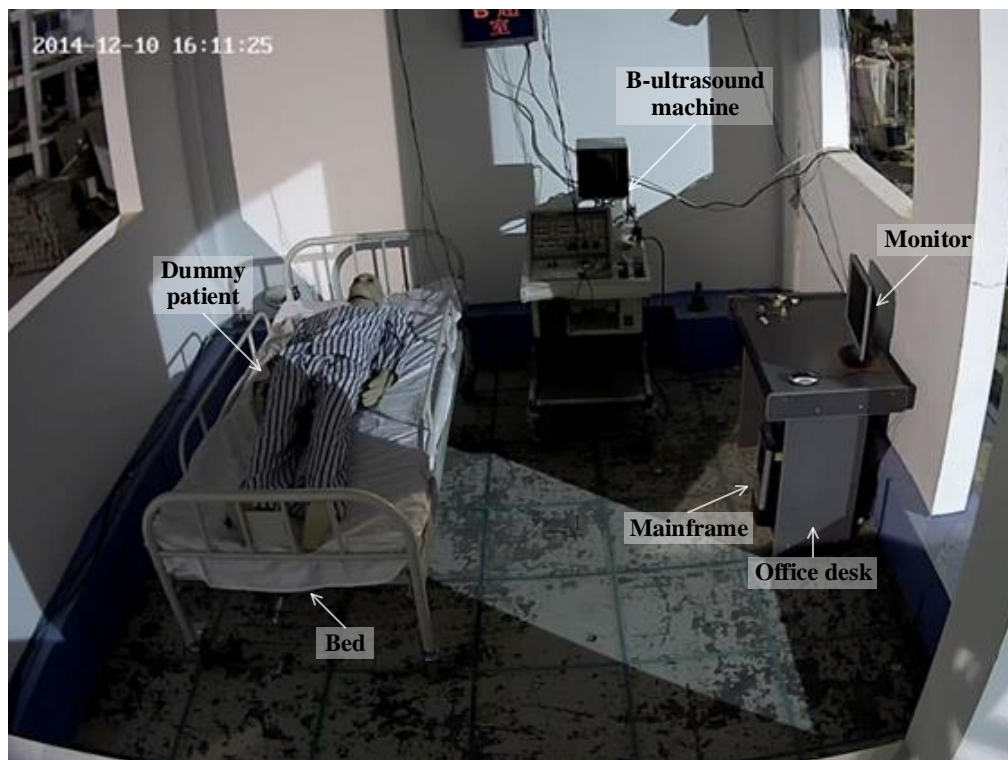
The B-ultrasound room model.
